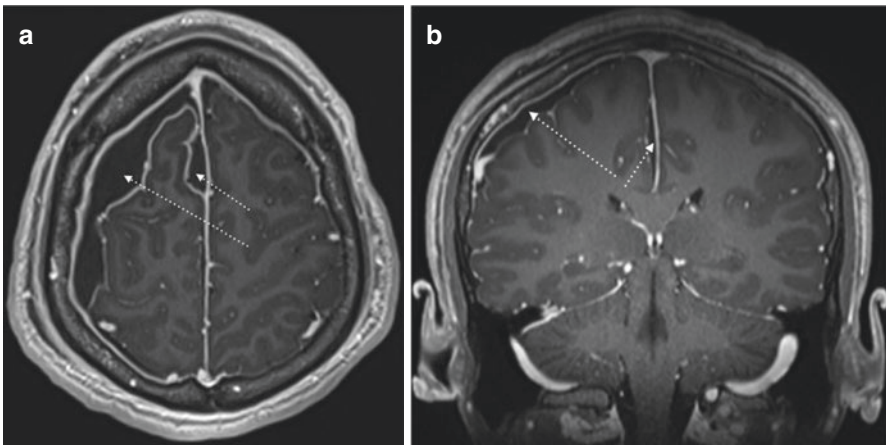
Post contrast MRI of subdural empyema. In these T1 post contrast MRI axial and coronal views, there is evidence of peripheral enhancement of a subdural collection in keeping with subdural empyema (broken arrows). Note also the presence of infection over the convexity in addition to the medial surface of the hemisphere. While convexity disease is manageable with a surgical intervention (i.e. Burrhole or craniotomy) directly over top the disease, interhemispheric disease may require indirect irrigation via placement of a catheter placed via paramedian craniotomy
